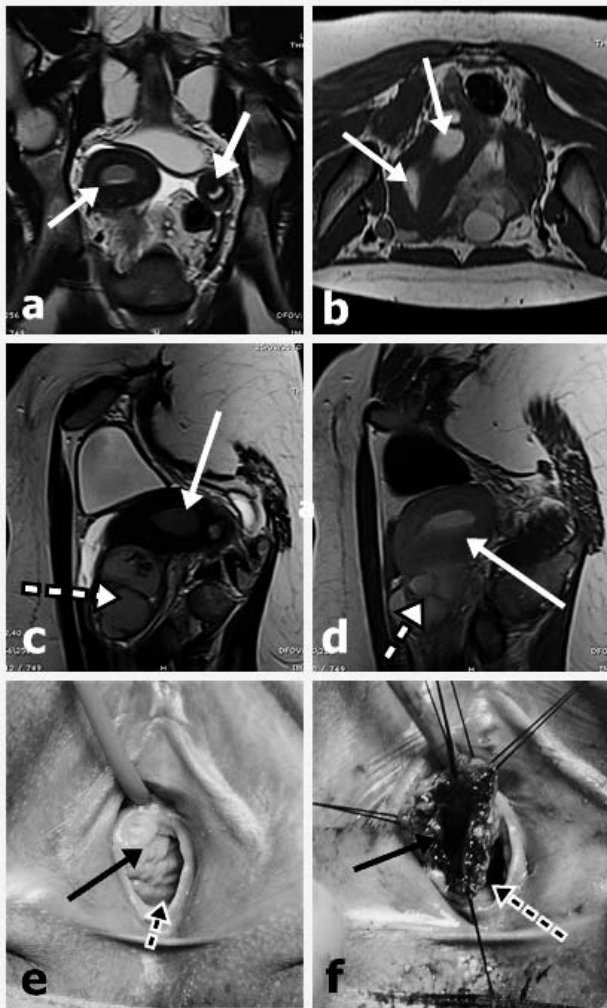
OHVIRA syndrome. A 14-year-old female patient presented with the triad of didelphys uterus (CIII), an obstructed right hemivagina, and ipsilateral renal agenesis. (a, b) Coronal and axial T2-weighted MRI demonstrated complete duplication of the uterine horns (arrows). (c, d) Sagittal T2-weighted MRI showed a distended right uterus (white arrows) with a transverse vaginal septum causing unilateral hematocolpos (dashed arrows). (e) Clinical examination demonstrated duplication of the vagina, forming a distended obstructed hemivagina (black arrow) and non-obstructed hemivagina (dashed arrow). (f) Surgical opening of the vaginovaginostomy. MRI, magnetic resonance imaging.
